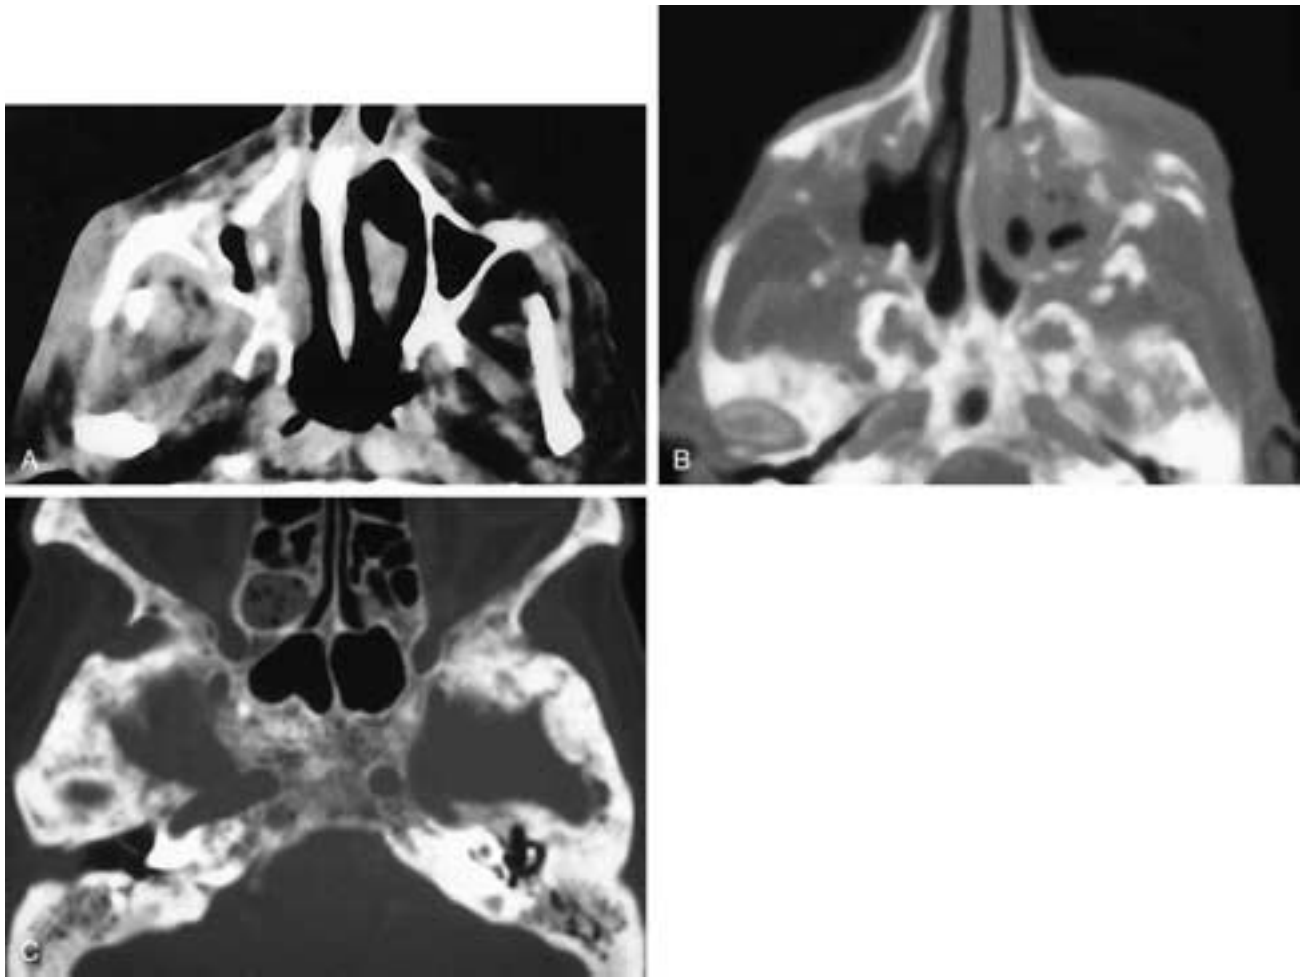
In A, an axial CT scan, there is fragmentation of the right maxillary sinus's bony walls, with sclerosis and thickening of the bone. Mucosal thickening is also present in the sinus. This patient had radiation osteitis and sinusitis. In B, an axial CT scan shows extensive sclerosis and fragmentation of the facial bones, with some of the osseous structures having been extruded as sequestra. This patient had radiation osteitis. In C, an axial CT scan shows areas of both dense bone and "washed-out," permeated-appearing bone in the skull base and posterior ethmoid and sphenoid sinus margins. Some secretions are also present in the most posterior right ethmoid cells. This patient had radiation osteitis after radiation therapy for a nasopharyngeal carcinoma.
